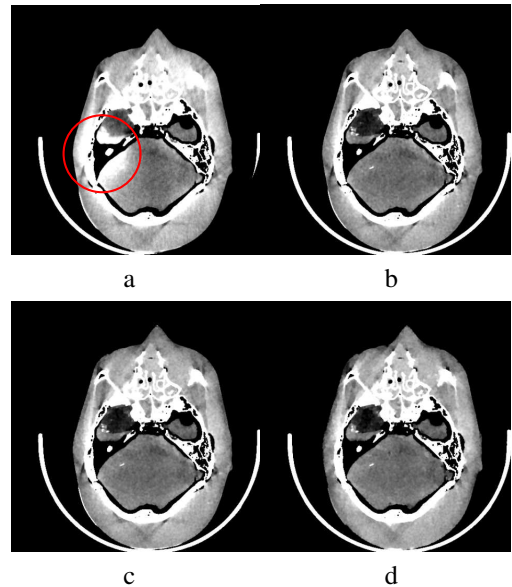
Images within a transverse slice reconstructed from 1200-view data by use of the FDK-type algorithm (a) and the CP algorithms for optimization programs with data- $\ell_2$  fidelity (b), data- $KL$  fidelity (c) and data- $\ell_1$  fidelity (d). A narrow display window, [0, 100] HU, is used to reveal the details of the cone-beam artifacts enclosed by the red circle.
